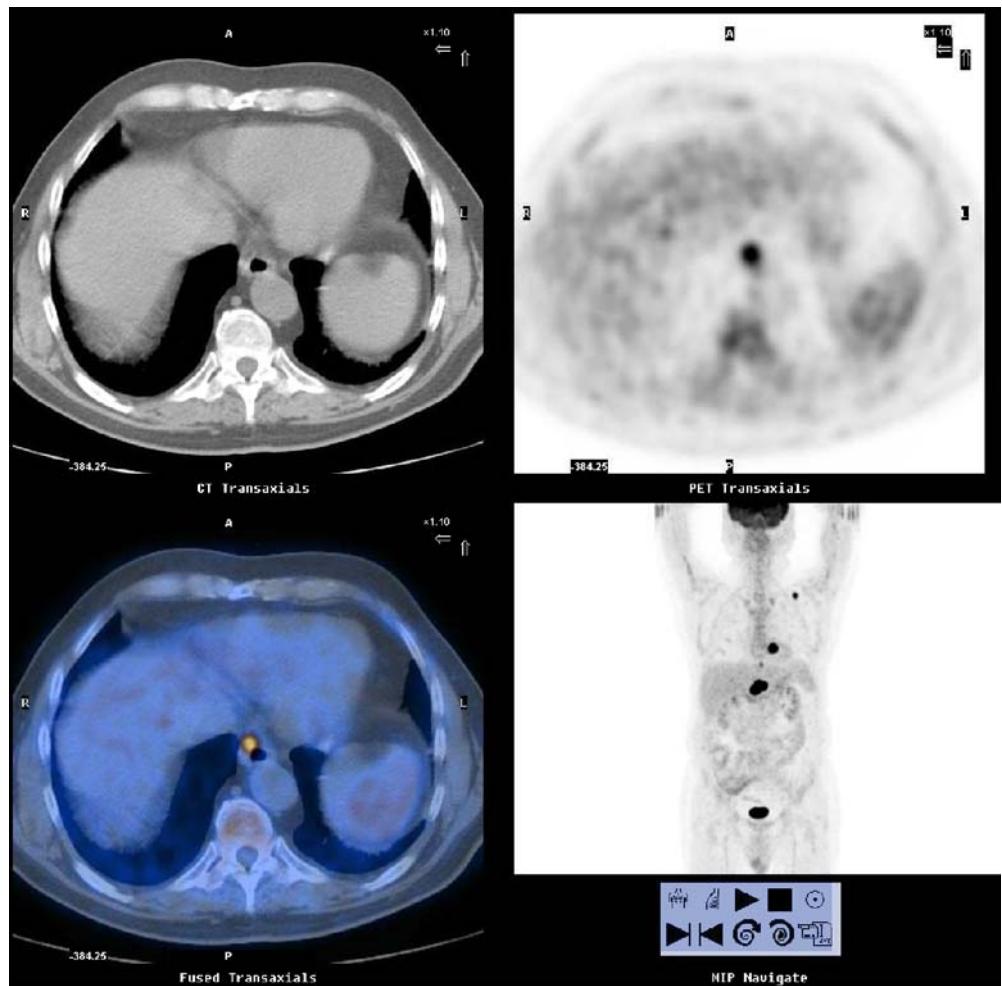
CT scan (top left), PET image (top right), PET-CT fusion image (bottom left) and 3D imaging in the anterior view (bottom right). There is focal and intense ^{18}F -FDG uptake in the lateral wall of the distal oesophagus, as well depicted on PET-CT. Moreover, an area of intense uptake is visualised in the left supraclavicular region. Subsequent endoscopy demonstrated the presence of a squamous cell carcinoma of the oesophagus, and the area of focal uptake in the left supraclavicular region was found to be a metastatic lesion
